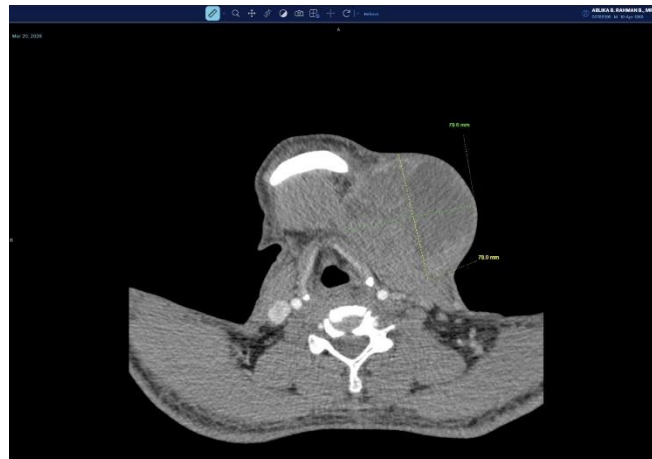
Contrast-enhanced CT of the neck following three cycles of TACE demonstrating a lobulated hypodense lesion
